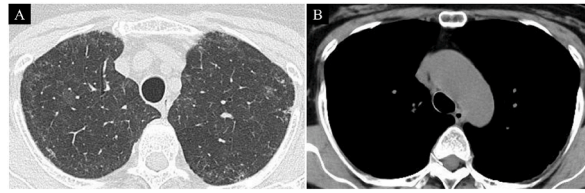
HRCT after initiation of treatment
